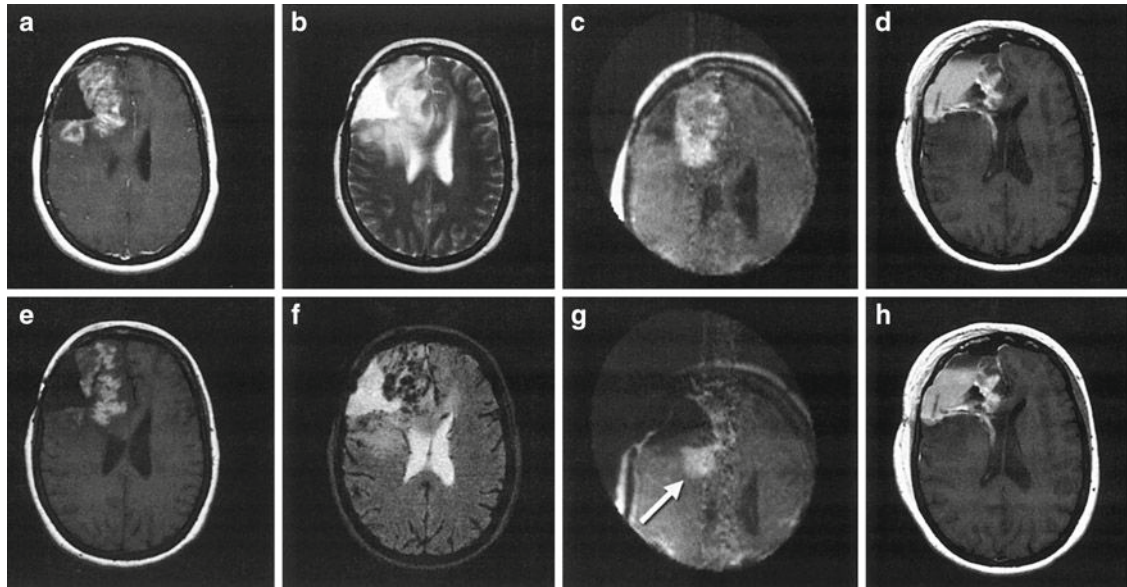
MR Images from a patient with glioblastoma including pre-, intra-, and postoperative images. (a) T1-weighted with gadolinium. (b) T1-weighted after ferumoxtran-10. (c) T2-weighted. (d) T2 GRE images after ferumoxtran-10. (e) Intraoperative MR image prior to surgery after ferumoxtran-10. (f) Intraoperative MR image during surgery after a partial resection. Residual lesion noted with arrow. (g) Postoperative T1-weighted images without gadolinium. (h) Postoperative T1-weighted images with gadolinium. Note the increased T1 signal in the resection cavity and from intraventricular hemorrhage
